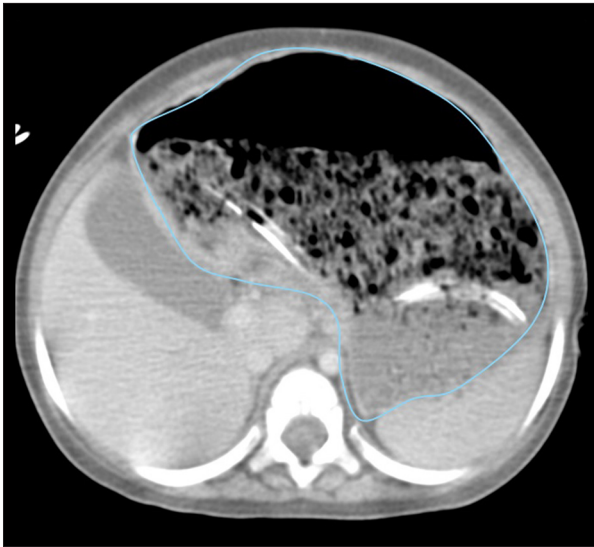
Abdominal CT with gastric dilatation with material inside.
